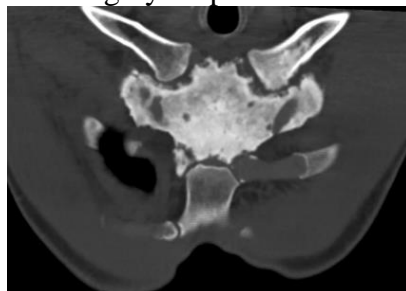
Chest CT showed sclerosis and destruction of the first sternocostal joints and sternoclavicular joints.
